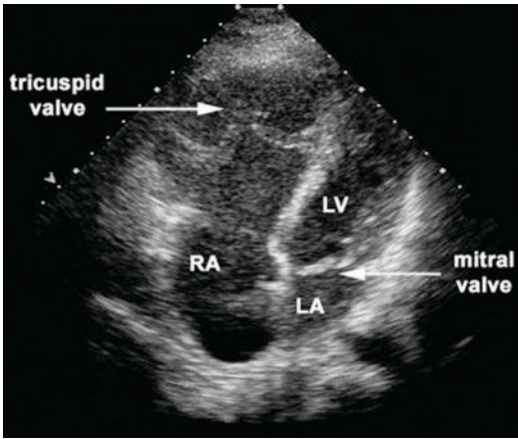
2D echocardiogram demonstrating Ebstein's anomaly
